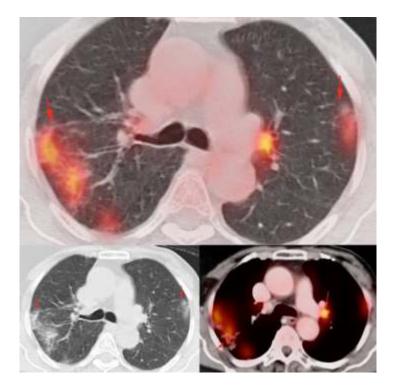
This 59-years old lady with carcinoma breast came for PET/CT. The CT scan shows typical COVID-19 changes with activity suggesting that this is recent disease with an active left hilar node – these nodes have been described in patients with COVID-19. Her RT-PCR test however was negative.
